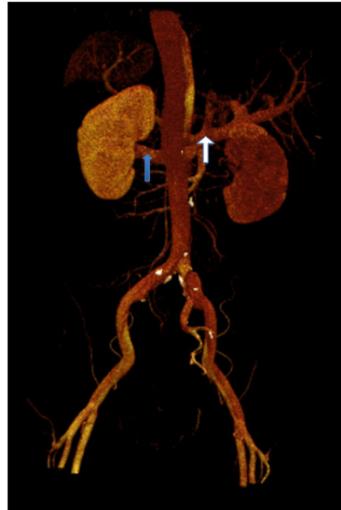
Still frame image of a Computed Tomography scan of the abdominal aorta with 3D reconstruction demonstrating an abdominal aorta dissection extending to the left femoral artery. There are two lumens in the abdominal aorta with the larger hypoperfused lumen giving rise to the right renal artery (blue arrow) and the smaller lumen perfusing the left kidney (white arrow). There is asymmetric opacification of the kidneys.
